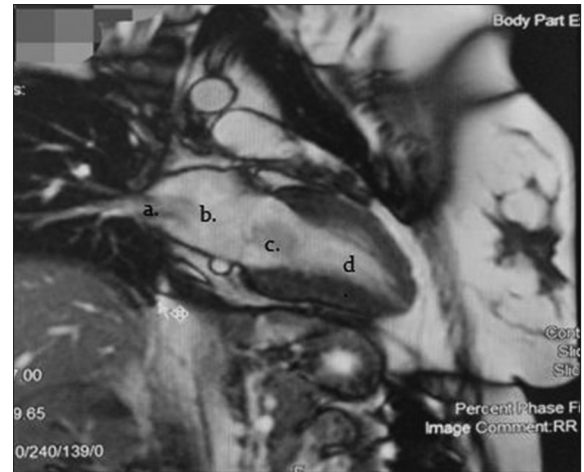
Cardiac MRI showing (a) pulmonary veins, (b) left atrium, (c) myxomatous mass, and (d) left ventricular cavity
